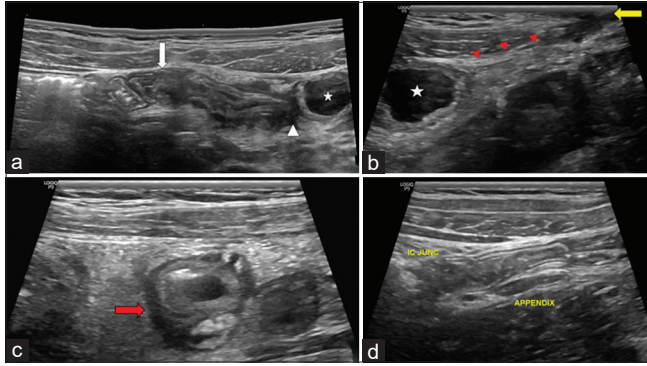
Sonogram of the lower abdomen of a 15-year-old boy using a linear high-frequency transducer show (a) A 4.5 cm long, blind-ending bowel loop arising from the ileum (white arrow) with a fluid-filled collection showing gut signature at its apex (white asterisk). Its posterior wall near the apex (white arrowhead) has a focal breach. (b) shows a fibrous band connecting collection (asterisk) tip (red arrowheads) to the umbilicus (yellow arrow). (c) The axial view of the diverticulum mimics a well-described pseudo gestational sac appearance of potential Meckel's diverticulum (red arrow). (d) Depicts a normal appendix and the ileocecal junction with their communication with the cecum.
